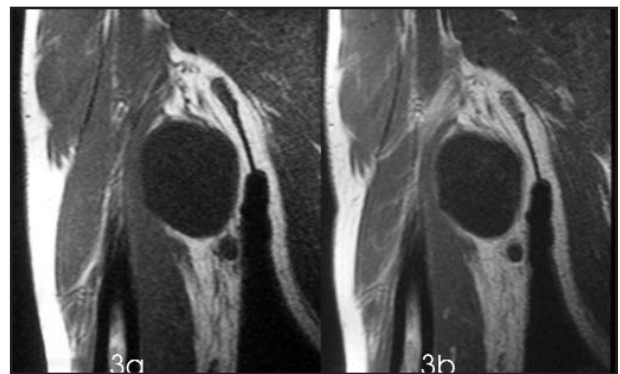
Sagittal T1-weighted pre- (a) and post-contrast (b) sequences demonstrating two of the well defined, oval, low signal intensity myxomas having thin internal septa, and moderate peripheral and septal enhancement. The peritumoural fat rind and fat caps are well demonstrated.
